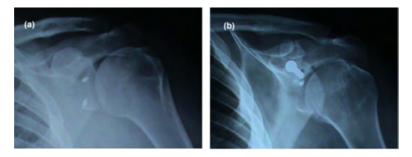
a. preoperative X-ray of shoulder instability previously treated by arthroscope (2 anchors) b. postoperative X-ray (the screw in glenoid and one anchor remaining)
